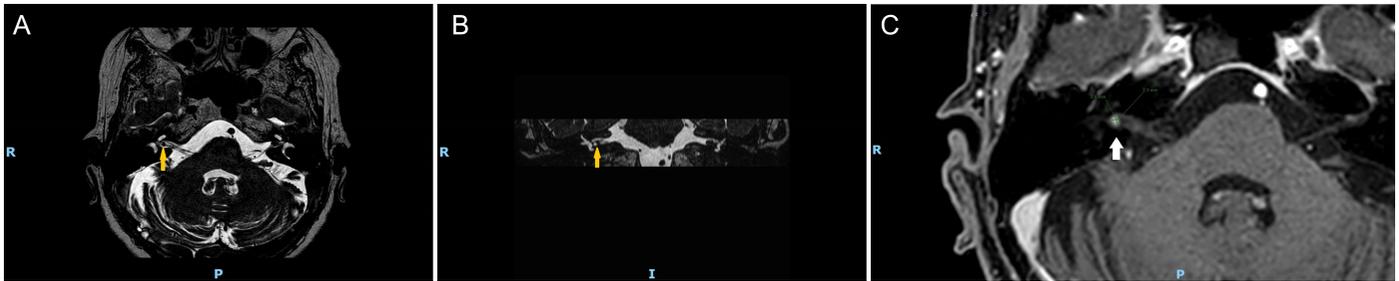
T1- and T2-weighted MRI with the yellow arrow (T2 images) pointing to the recently appeared right intracanalicular VS. (A) axial T2; (B) coronal T2; (C) axial T1. MRI, magnetic resonance imaging; VS, vestibular schwannomas.
